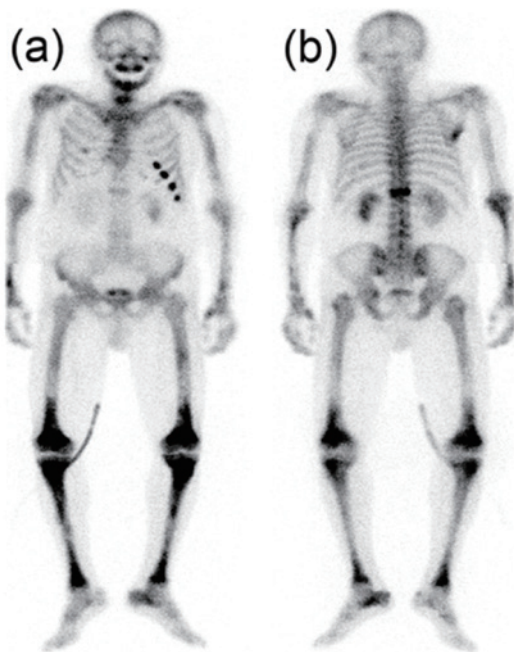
Technetium 99 (^{99m}Tc) bone scintigraphy. (a) Anterior. (b) Posterior. ^{99m}Tc bone scintigraphy shows high integration in the long bones, scapulae, and ribs.
